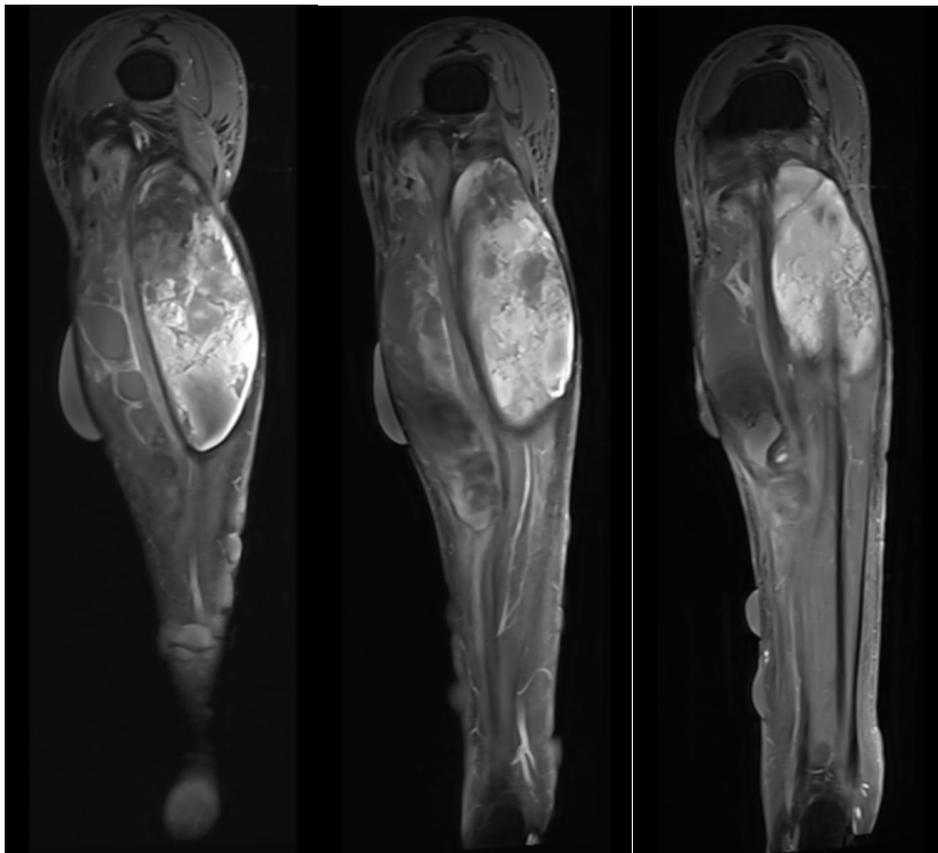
MRI left leg T2W coronal view
